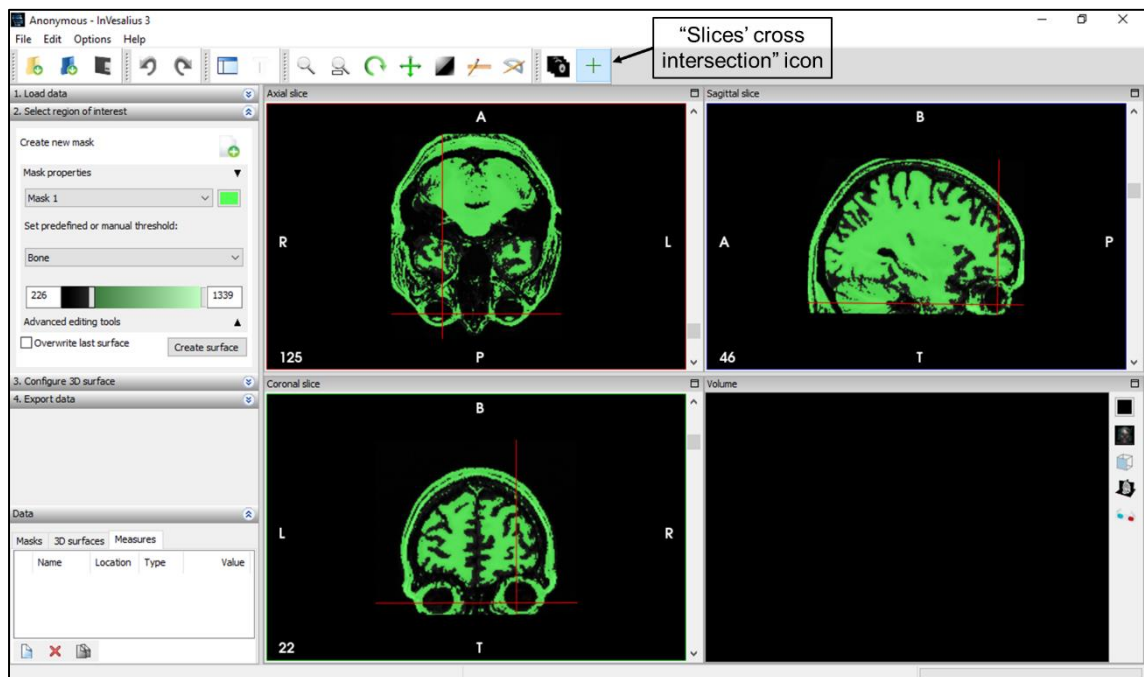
MRI images from different anatomical planes with slices' cross intersection line.
